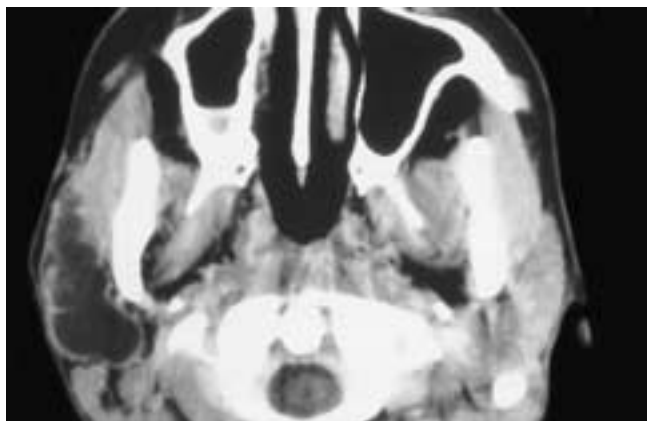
Axial postcontrast CT scan shows a large cyst occupying almost the entire right parotid gland. This cyst developed in a partially obstructed gland secondary to a stricture near the hilum of the gland. This patient had an obstructive cyst (mucocoele, sialocoele).
